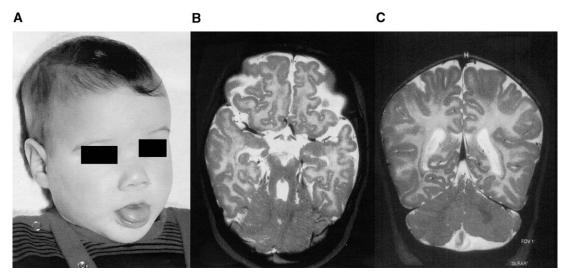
Joubert syndrome. (A) Photograph of a 3-year-old boy with Joubert syndrome. Note the medial rotation of the eyes and the tongue protrusion. T2-weighted MRI scans in axial (B) and coronal (C) projections depicting the typical "molar tooth sign" in B and the missing fusion of the hemispheres because of aplasia of the vermis in C. (Courtesy of Prof. E. Boltshauser, Zürich, Switzerland.)
